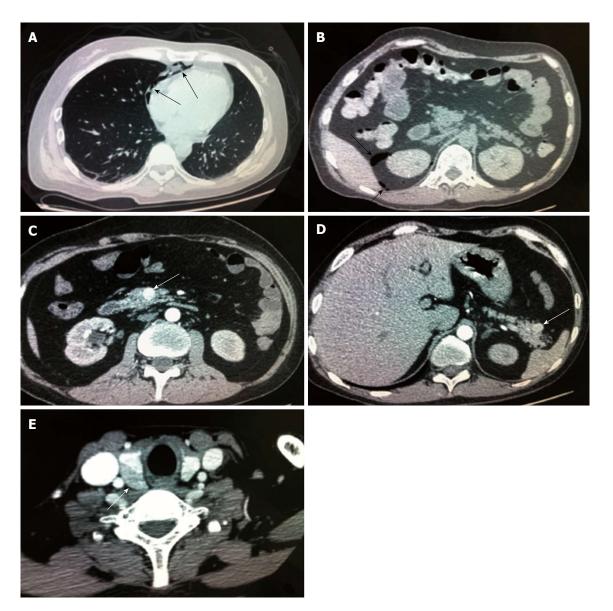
Computed tomography scan of the case. A: Chest Computed tomography (CT) shows a mediastinal emphysema (arrows); B: Epigastric CT shows accumulation of gas and fluid (arrows) in the anterior pararenal space just adjacent to the thickened wall of the horizontal part of the duodenum as well as accumulation of gas in the right perirenal space; C, D: A small intestine CT shows bowel wall thickening and strong enhancement of the horizontal part of the duodenum and a nodular mass (arrows) with a rich blood supply in the uncinate process (C) and tail (D) of the pancreas; E: Thyroid gland CT shows mild nodular goiter with nodules (arrow) posterior and lateral to the thyroid gland.
